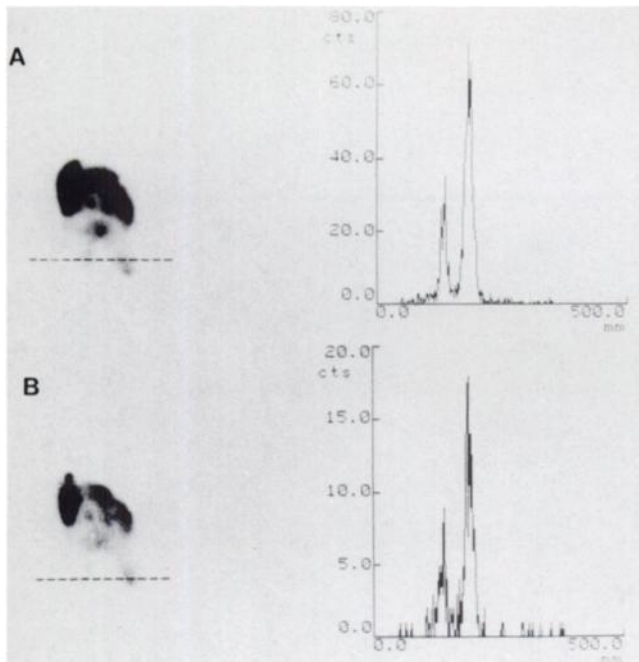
Count profile across the medial and lateral knee compartments 24 (A) and 48 (B) hr following intra-articular injection with ^{153}Sm -PHYP. The profile curves (cts/pixel) from coronal slice SPECT images shown on the right suggest similar patterns of activity distribution.
